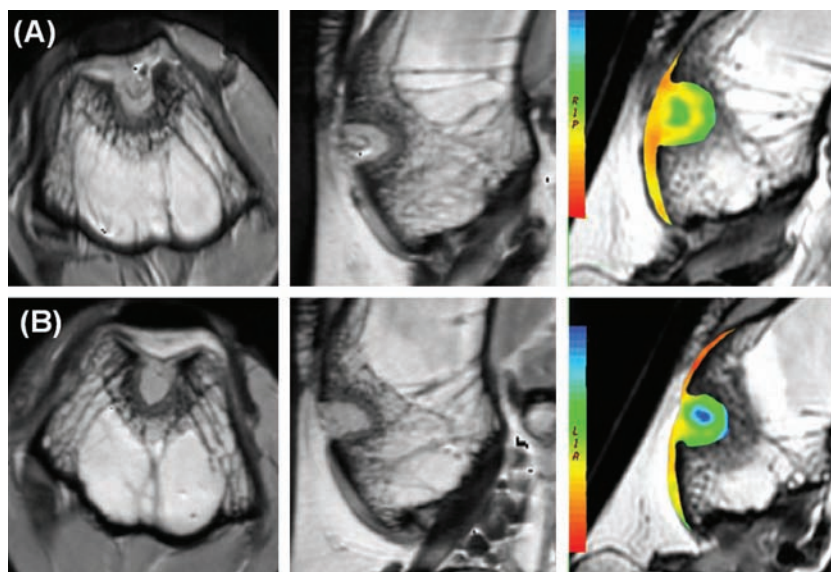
Axial and sagittal cartilage-sensitive fast spin echo magnetic resonance images and corresponding sagittal T2 maps demonstrating sites of cartilage repair by (A) thrombin peptide (TP)-508 and (B) placebo at 6 weeks. Color images available online at www.liebertonline.com/ten.
